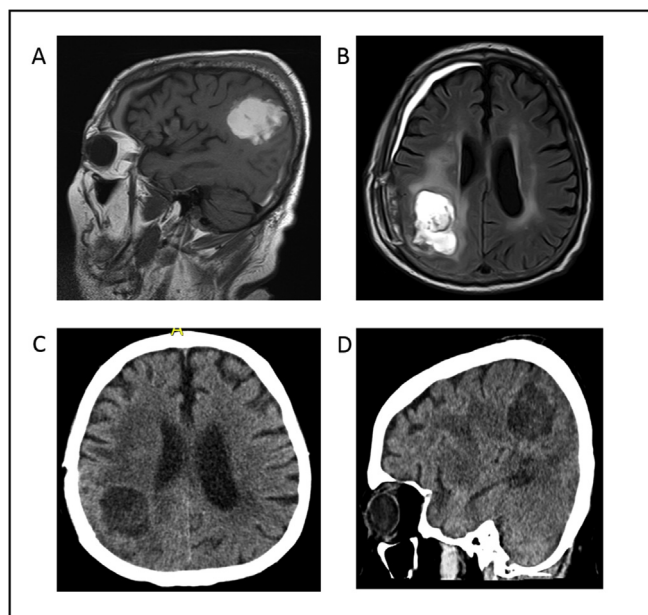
Magnetic resonance images: intra-axial lesion with expansive behaviour, 28 mm in diameter, with ring enhancement and associated vasogenic oedema, located in the right parietal lobe; area of right anterior subsinsular vasogenic oedema without enhancement.
